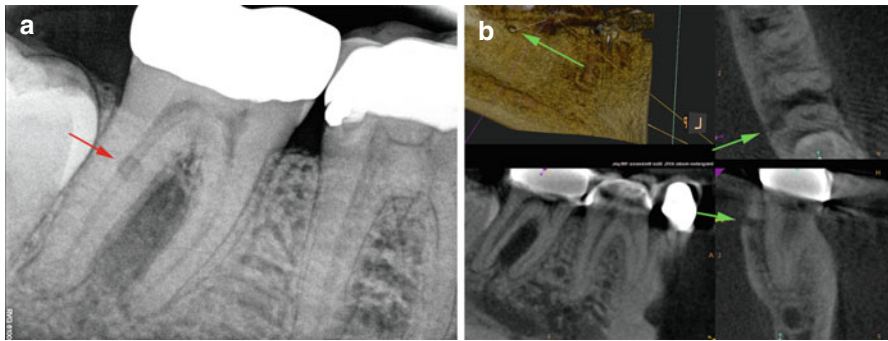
(a) Periapical radiograph of a mandibular second molar tooth showing a radiolucency overlying the distal canal; (*red arrow*) (possibly external root resorption). (b) CBCT of the same tooth showing that that region of radiolucency is a defect in the lingual cortical plate of the mandible; (*green arrows*)
